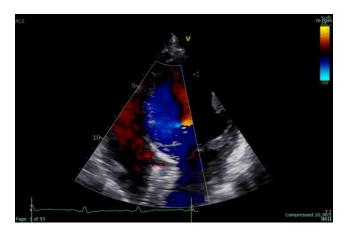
Transthoracic echocardiography – apical 4 chamber view: the strong echo of the occluder in the atrial septum is seen with no apparent Color Doppler flow at the atrial level
